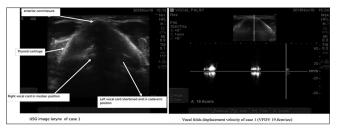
Ultrasound image of the first patient
